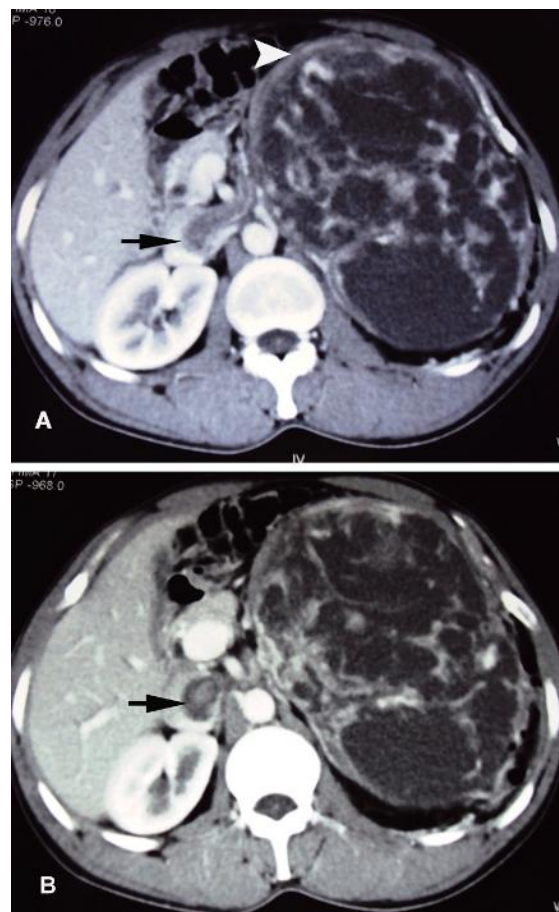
A) & B) Axial spiral CT scan of abdomen at two different levels showing large heterogeneously enhancing mass lesion occupying the entire non functioning left kidney (White arrow head) with a non-enhancing thrombus in the left renal vein extending up to the inferior vena cava (Black arrow).
